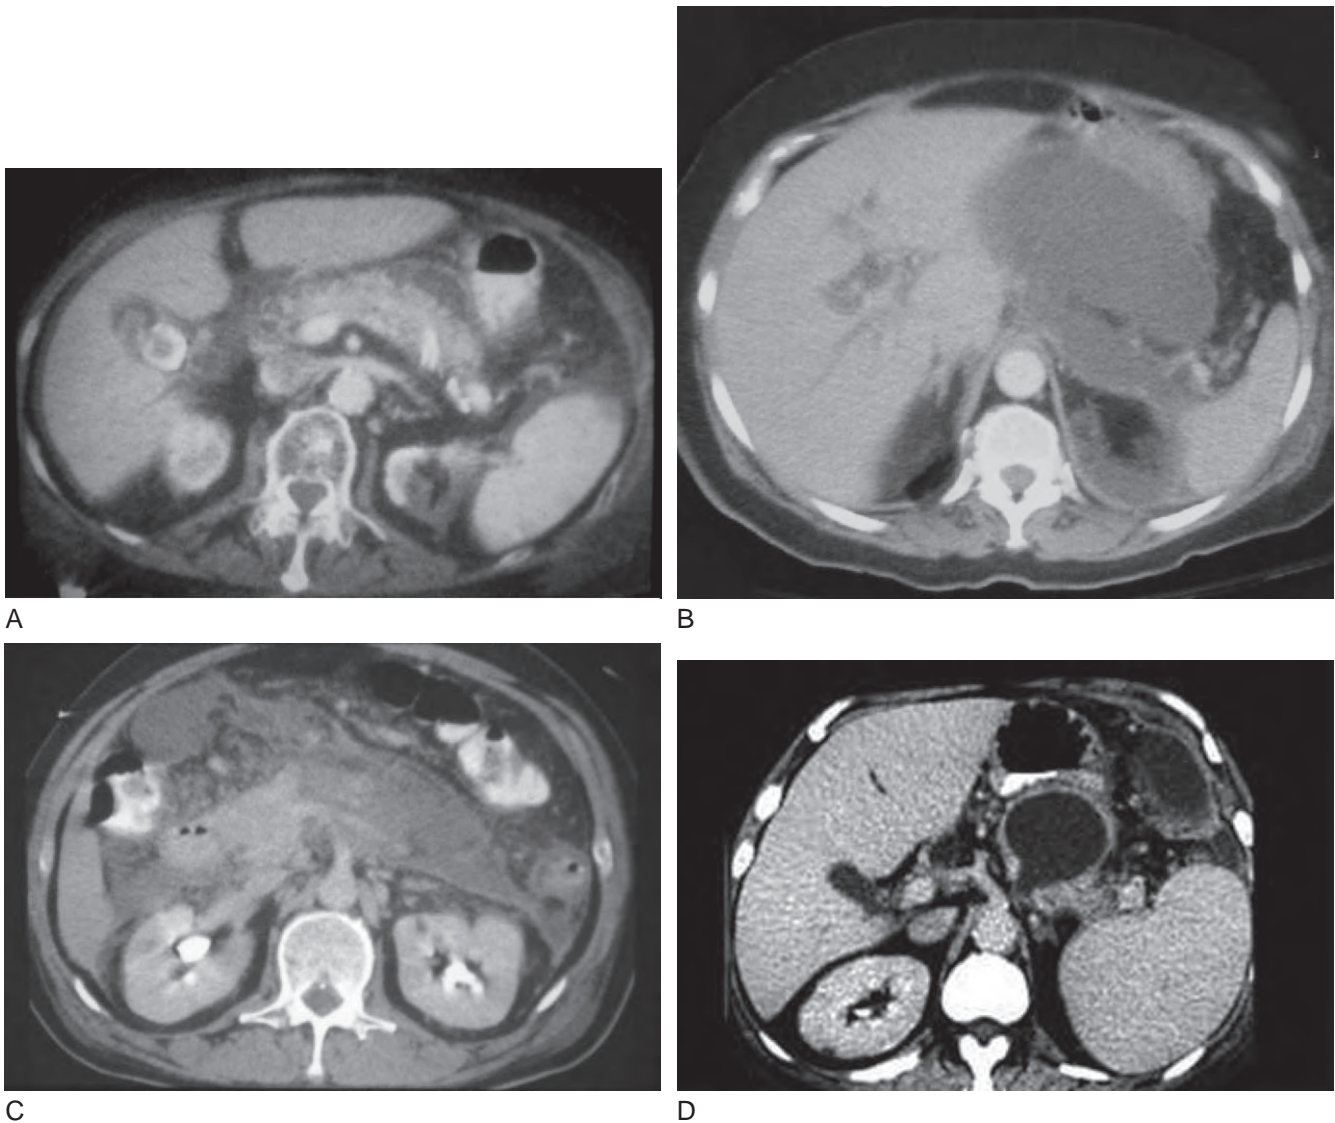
A, In mild acute pancreatitis, the fully enhanced pancreas shows interstitial edema; mild fat stranding is seen in the peripancreatic tissues. (A, From Simms M, Johnson D: Diagnosis of necrotizing pancreatitis using contrast-material-enhanced CT. *Probl Gen Surg* 13:14, 1996.) B, Acute fluid collections are poorly defined collections in the lesser sac and are a distinct clinical and radiologic entity from pancreatic pseudocysts. C, Necrotizing pancreatitis is characterized by the absence of enhancement of the parenchyma with intravenous contrast. The head of the pancreas enhances with contrast, whereas the body and tail do not. Note the moderate amount of fat stranding in the peripancreatic soft tissues. D, A pancreatic pseudocyst has a well-defined wall of fibrous or granulation tissue and contains clear pancreatic fluid. Note the absence of inflammation in the surrounding tissues.
